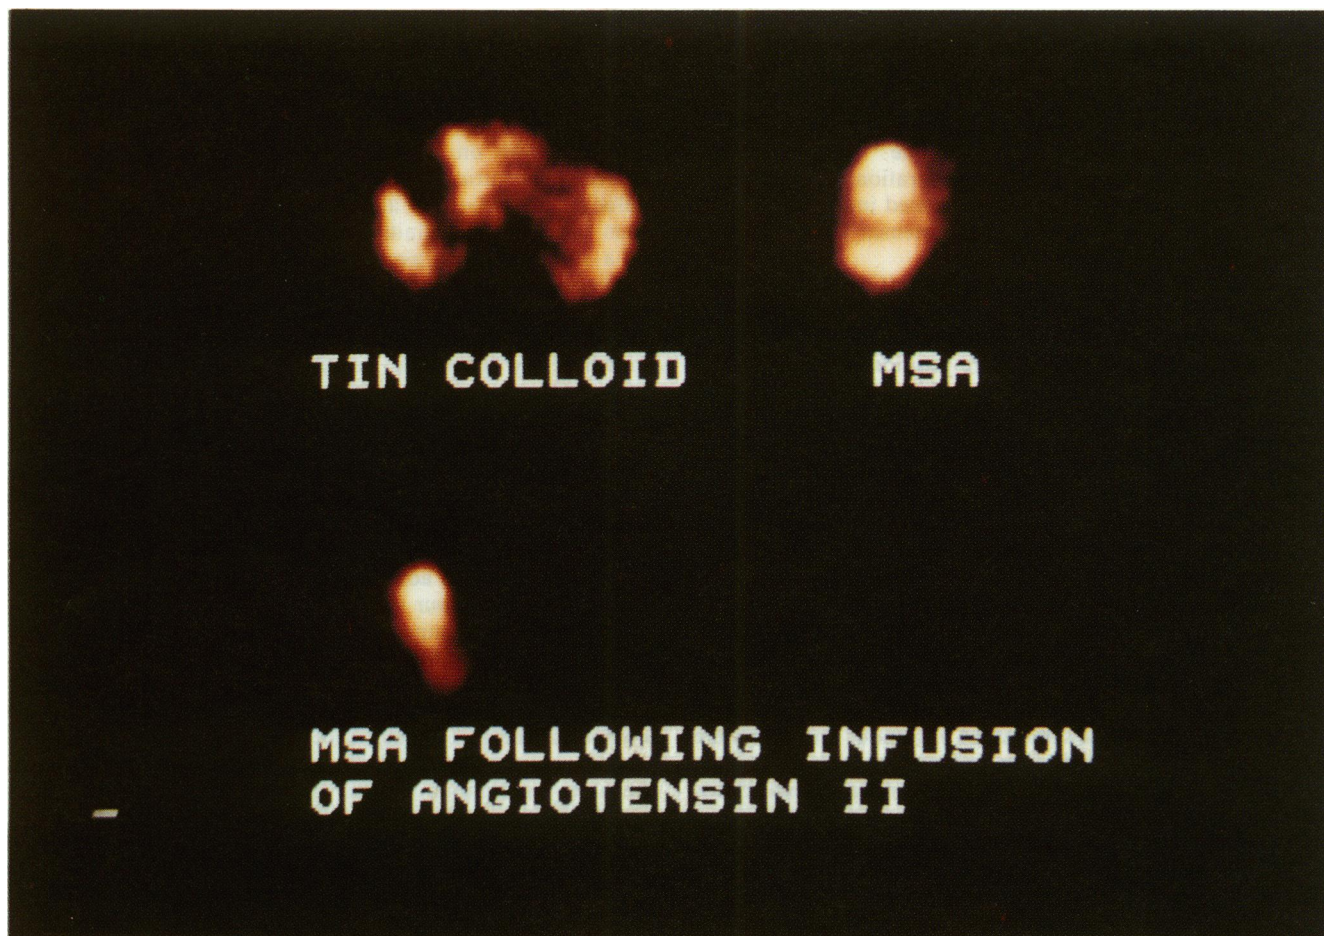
Comparative transaxial slices (same studies as Figure 1): (i) Albumin colloid. (Top left). (ii) Hepatic arterial perfusion scintigraphy. (Top right). (iii) Angiotensin II enhanced hepatic arterial perfusion scintigraphy. (Bottom).
